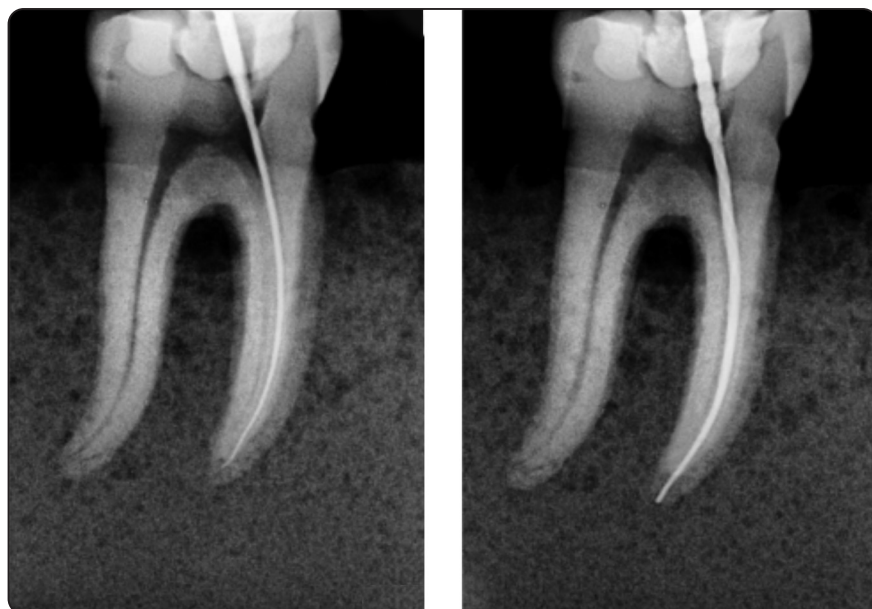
showing Pre-instrumentation periapical x-ray and Post instrumentation periapical x-ray.
